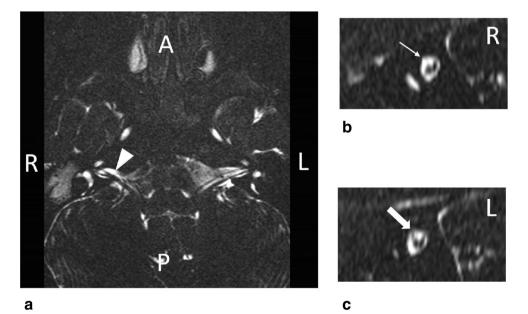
MRI of patient 6 performed in 2013. a Axial 0.4-mm 3Dconstructive interference in steady state (3D-CISS) sequence shows a hypoplastic right facial nerve (white arrowhead). It is important not to confuse the anterior inferior cerebellar artery (AICA) loop in the internal auditory canal (IAC) with a nerve. b Parasagittal 0.5-mm reconstructions
